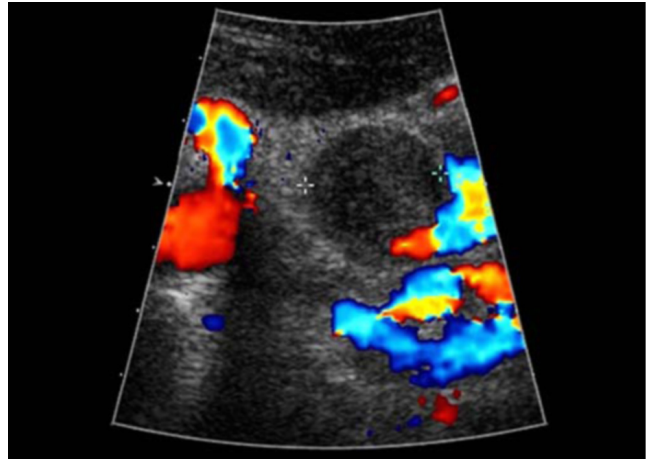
Ultrasound image with color Doppler demonstrates turbulent flow within the splenic artery aneurysm (arrows) before thrombin injection.
